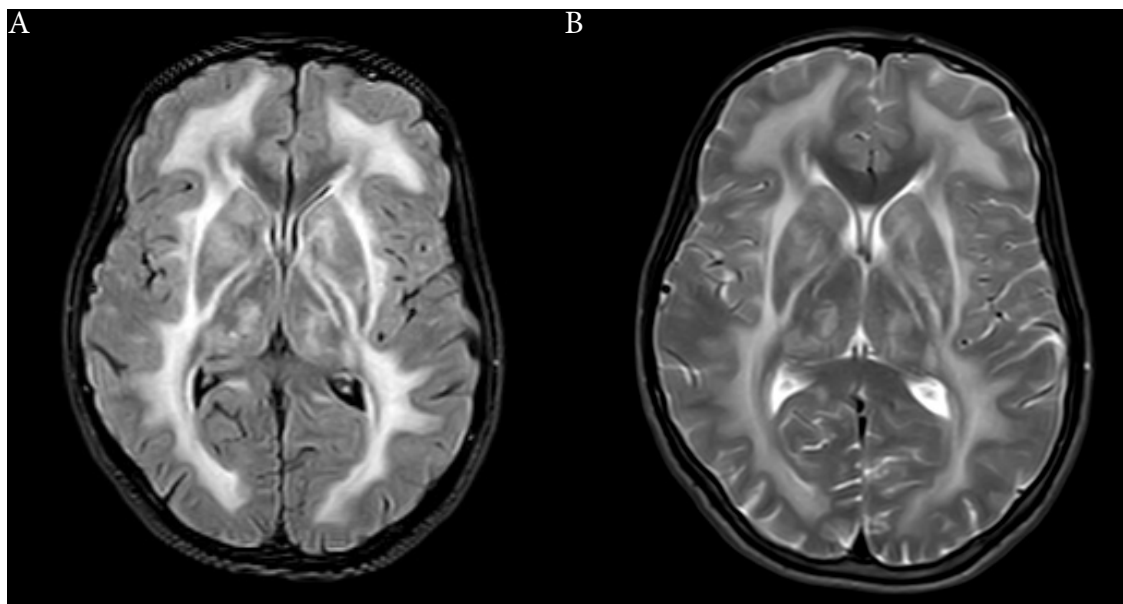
Brain MRI showing the evidence of symmetrical hyperintensity in white matter in both hemispheres was noted in the T2-weighted image (A). Also, there were areas of hyperintensity in both the basal ganglia and the thalamus in the T2-weighted image (B)
